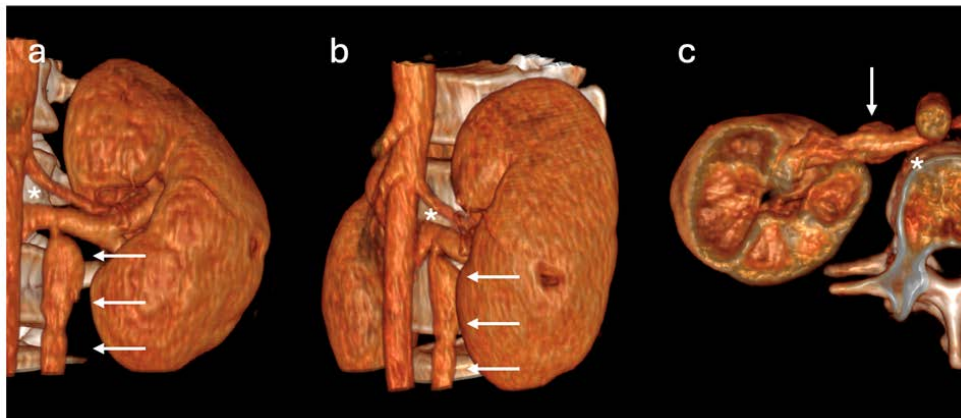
3D reconstructions: Retroaortic left renal vein (*asterisk*) and the dilated ovarian vein (*white arrow*) in coronal (*a*), sagittal (*b*), and axial (*c*) 3D reconstructions of the CT scan (218 mAs, 80 kV, 1.25 mm slice thickness, portal venous phase after intravenous injection of 80 mL of iodinated contrast agent (Iohexol 300 mg I/mL).
